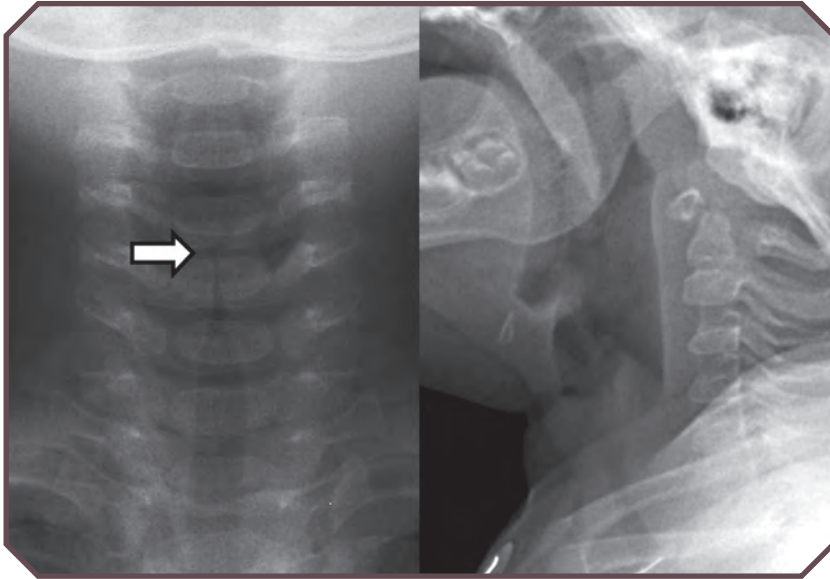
Croup. A. Frontal radiograph of the neck shows subglottic narrowing, or the steeple sign (arrow), which is classic for croup. B. Lateral radiograph shows a normal epiglottis and narrowing of the subglottic space. Courtesy of E. M. Comiskey, MD, Rush University Medical Center, Chicago, IL.
